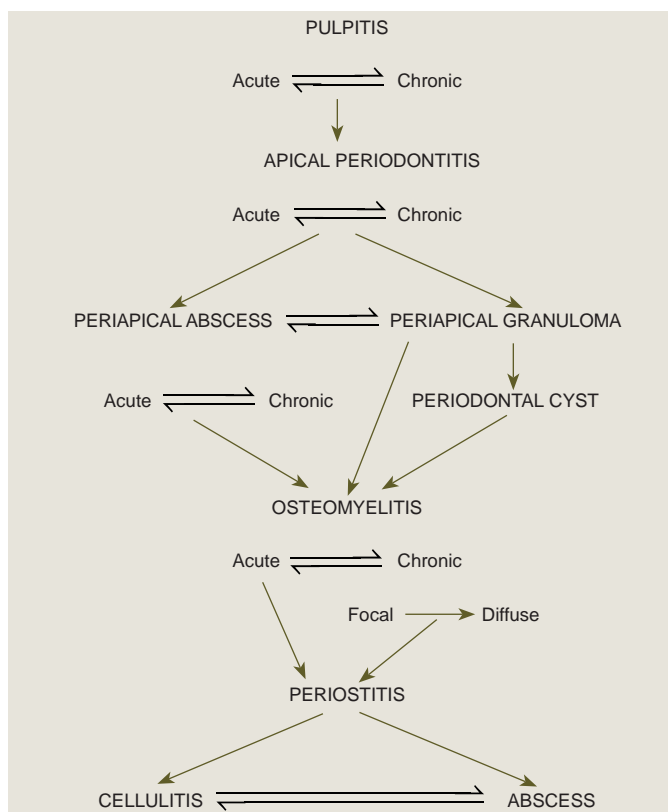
Interrelationships of periapical infection.
